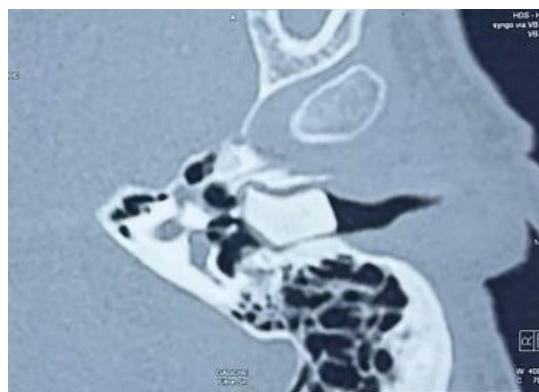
Non-injected CT scan of the temporal bone (axial section) showing a well-ventilated mastoid with no signs suggestive of mastoiditis, and no indirect signs of labyrinthitis.
